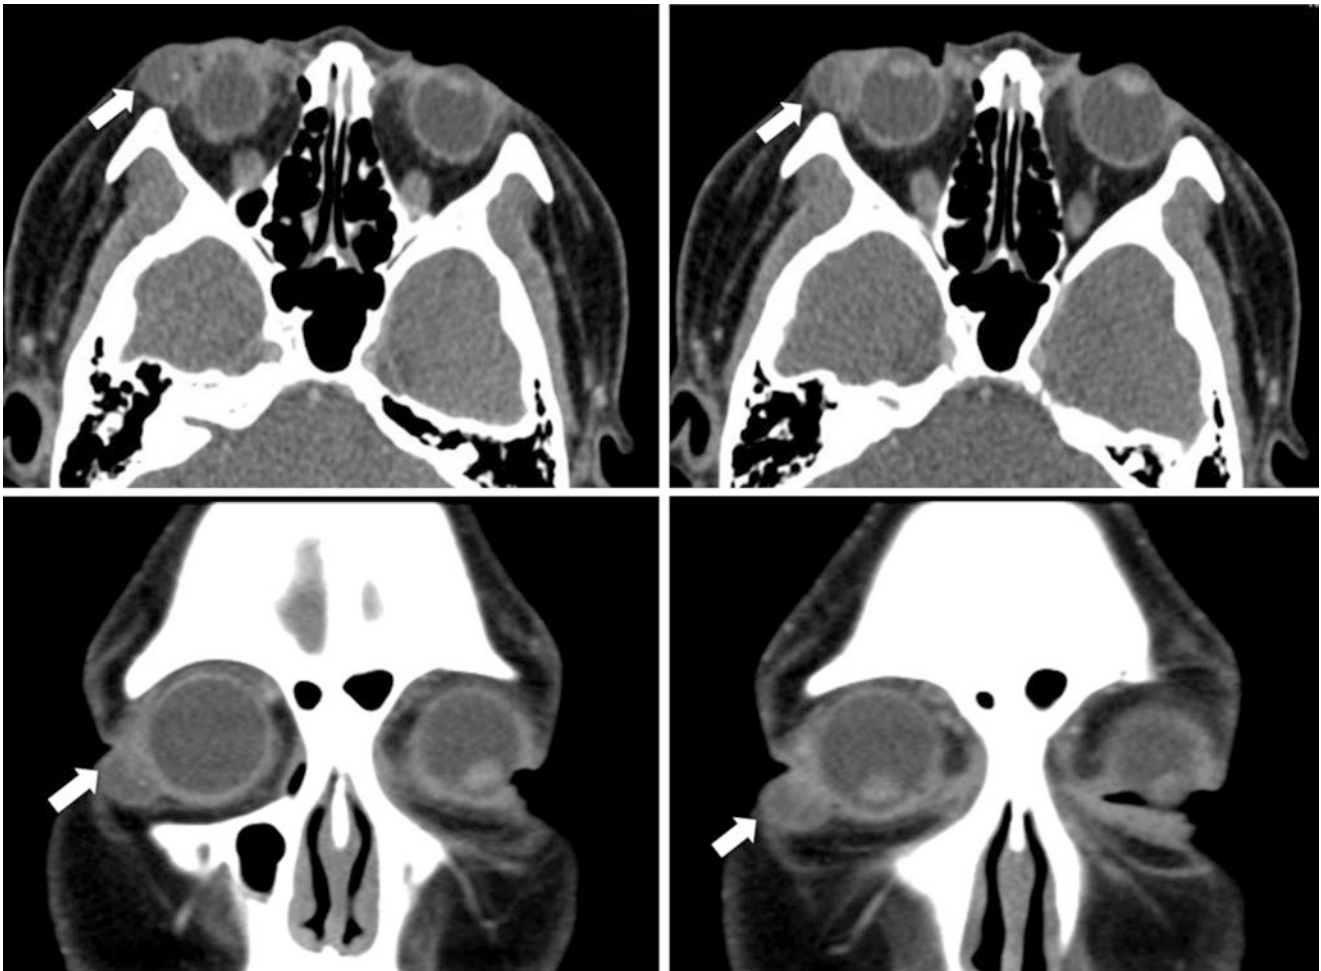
Axial (above) and coronal (below) contrast-enhanced CT scans of the orbits showing the mass (arrows) in the anterolateral preseptal/eyelid region abutting the globe. It is centrally hypodense, indicating a cystic component
